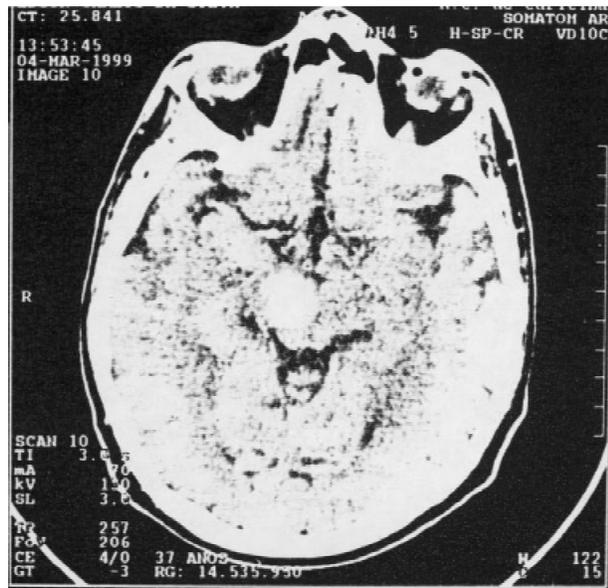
Cranial computed tomography scan demonstrated an expansive lesion, with contrast enhancement, in the right side of the midbrain.
